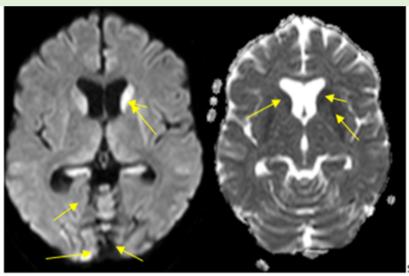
MRI Learning points:
